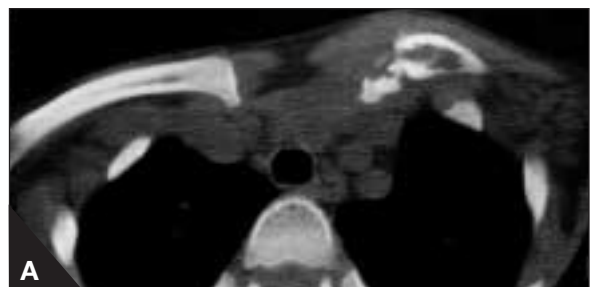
Axial CT scans of the (A) medial shafts of the clavicles and (B) sternoclavicular joints.
